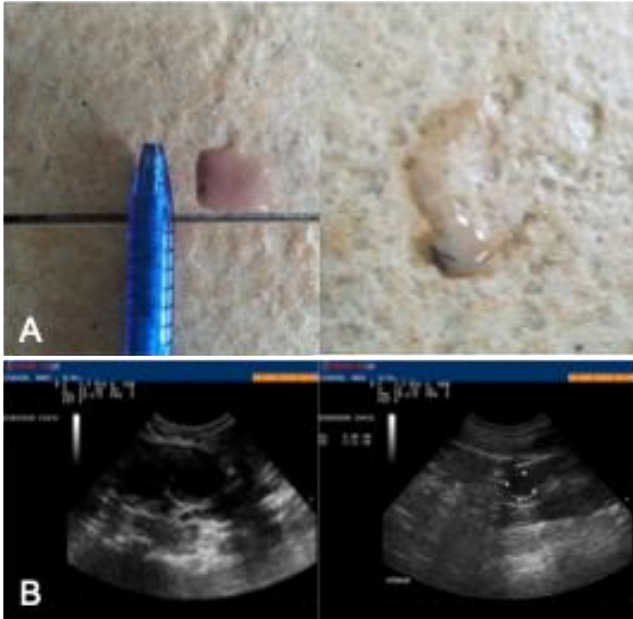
(A) Bloody mucopurulent vulvular discharge on the night stall floor was discharged by Chemon, a 20-year-old female Malayan tiger (*Panthera tigris jacksoni*) in captivity at the National Wildlife Rescue Center (NWRC), Malaysia; (B) Fluid-filled uterus revealed by ultrasonography.
